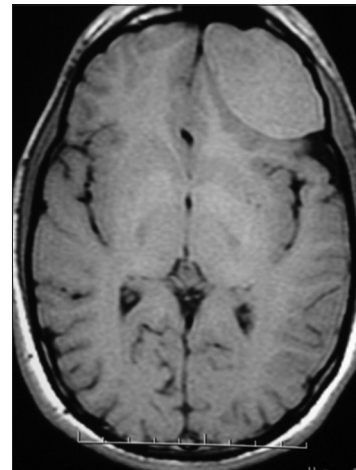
T2-weighted magnetic resonance imaging image showing extradural hematoma in the left frontal region
